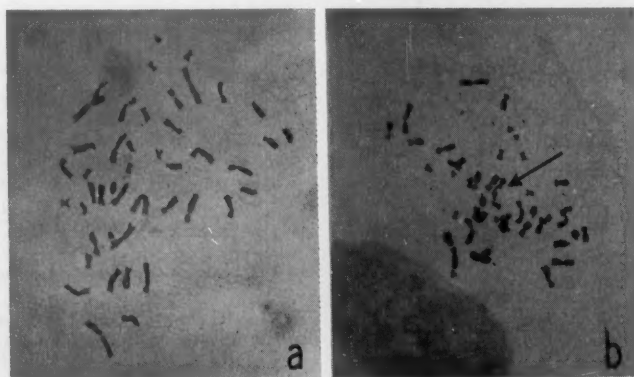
Colchicine-treated metaphase figures from tissue cultured epithelioid diploid human kidney cells. (a) Normal figure from control material. (b) A figure from the 42-hour, 25-roentgen series, showing a chromatid deletion (arrow).
